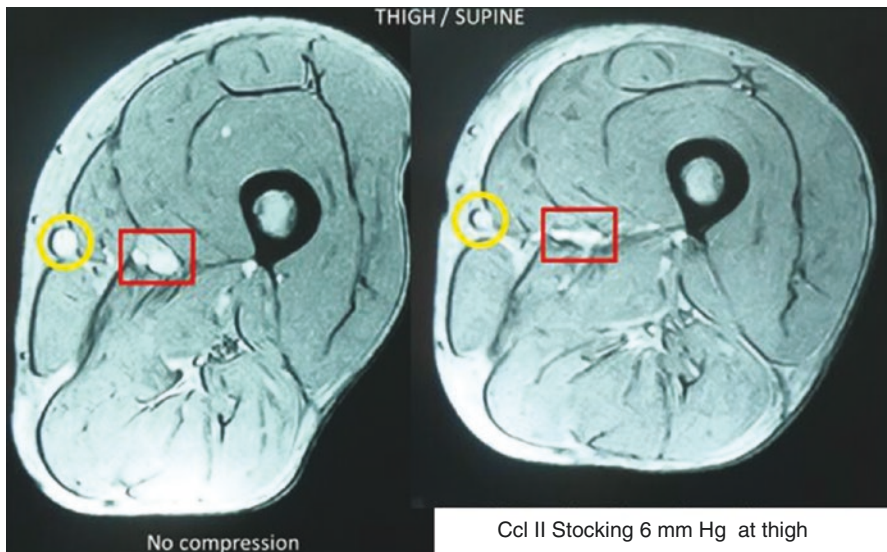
MRI-cross section of a thigh without (left) compression and under a TPS stocking exerting 6 mmHg over this thigh segment (right) [46]
